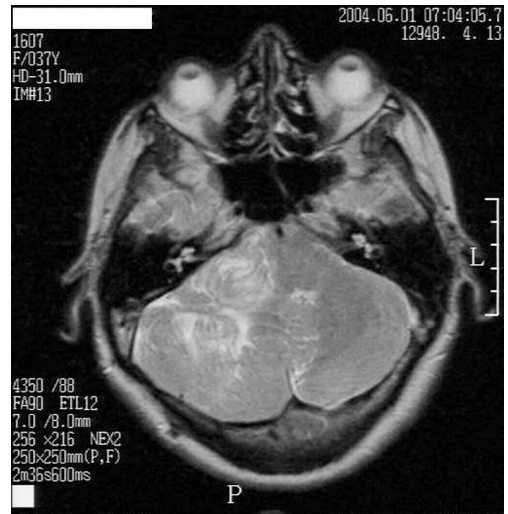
Axial T2-weighted image (SE 4350/88) demonstrates a typical "tiger-striped" pattern of the lesion with compression of the fourth ventricle.
